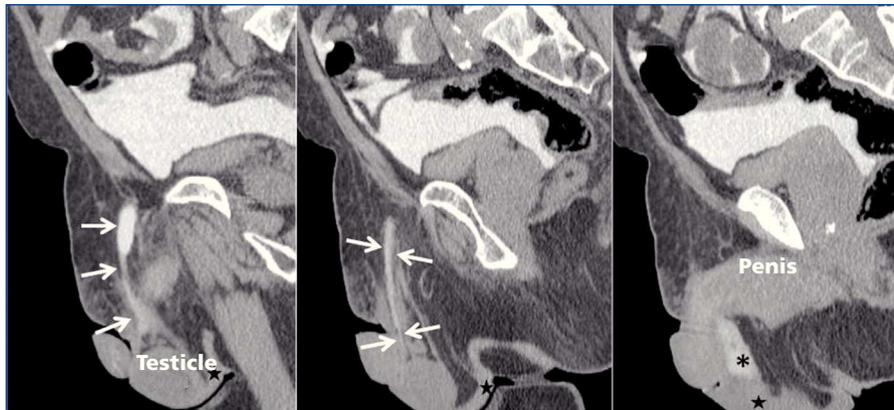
CT peritoneography.
